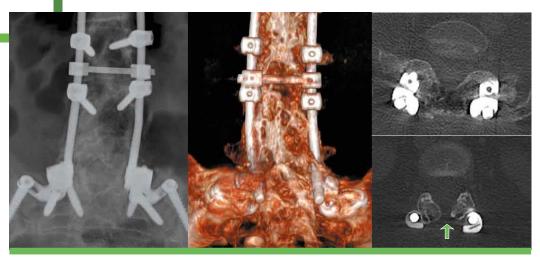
X-ray and CT lumbar puncture in a patient with significant ankylosis.
